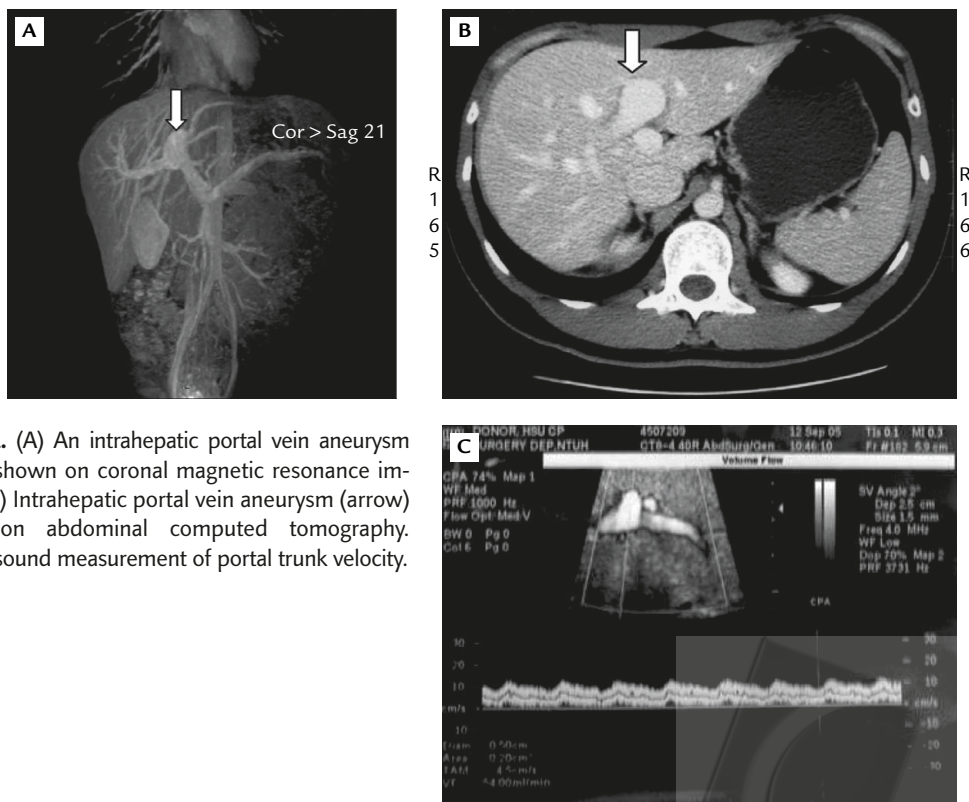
(A) An intrahepatic portal vein aneurysm (arrow) shown on coronal magnetic resonance imaging. (B) Intrahepatic portal vein aneurysm (arrow) shown on abdominal computed tomography. (C) Ultrasound measurement of portal trunk velocity.
